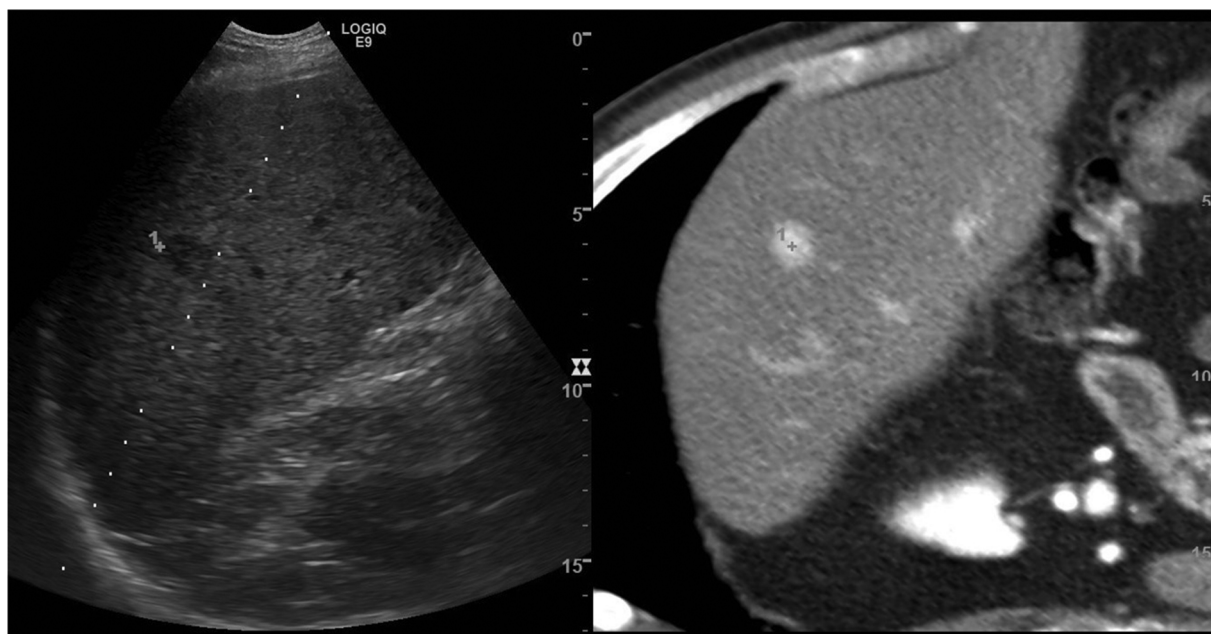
Liver tumour with arterial loading on computed tomography fused with live ultrasound for easier targeting.
